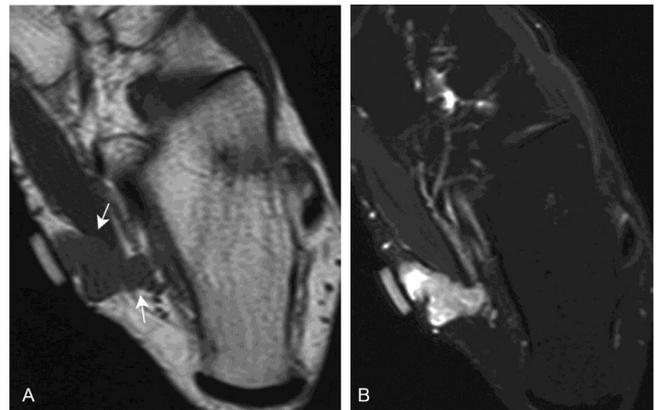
Schwannoma. Axial long-axis T1WI (A), and fat saturated T2WI (B) show a lobulated mass arising from the tarsal tunnel (white arrows in A). The mass has iso signal to the muscle on T1WI, and high signal on T2WI. T1WI, T1-weighted images; T2WI, T2-weighted images.
